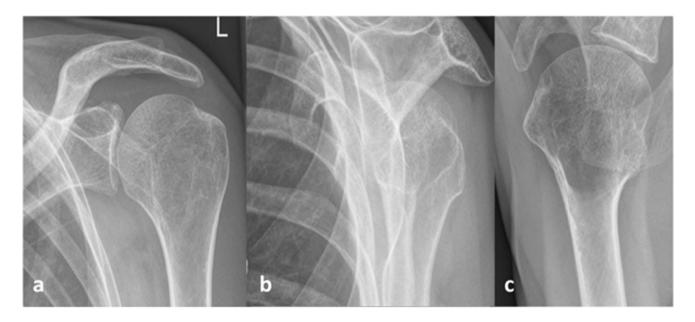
Radiographic process of fracture healing was without complication. X-ray after 1 year in AP (a), scapular-Y (b), and axillary (c) views. Nevertheless, clinical convalescence remained poor. CS: 18 points, SSV: 30%
